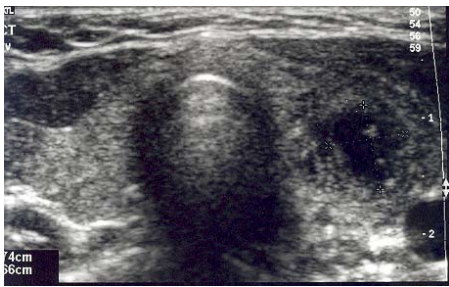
Transverse ultrasound image of the thyroid gland shows abscess involving the left lobe and adjacent perithyroid soft tissue.
